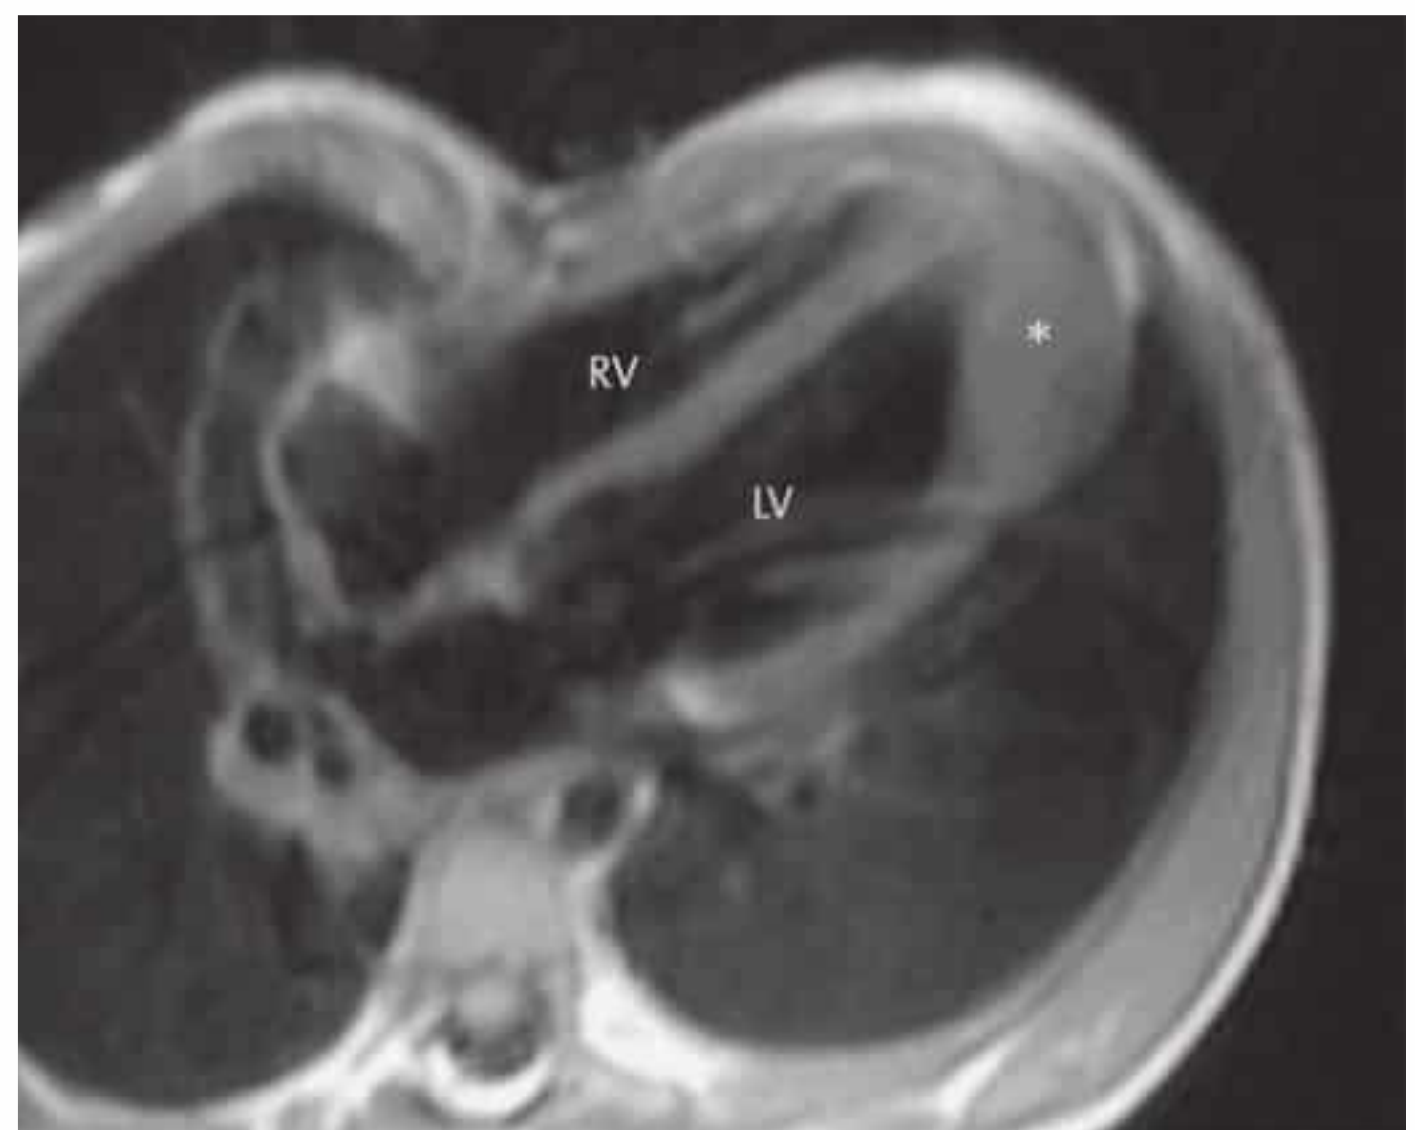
Rhabdomyoma in the apical lateral wall. T2-weighted MRI displays the tumor as a well-circumscribed homogeneous mass that is isointense to myocardium.
